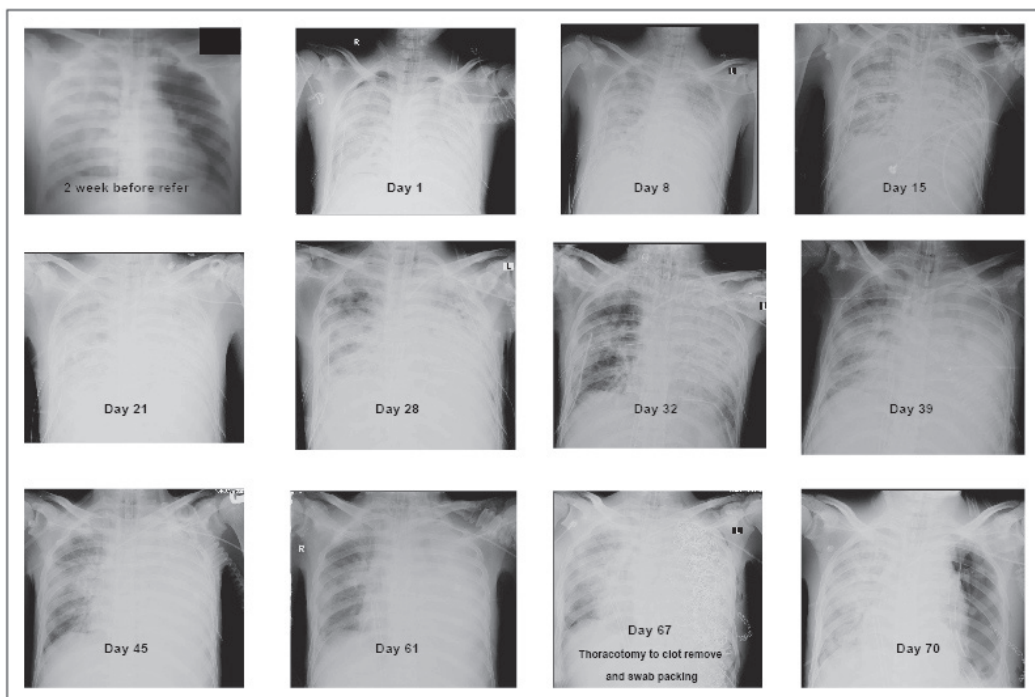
Chest X-ray of patient during admission
